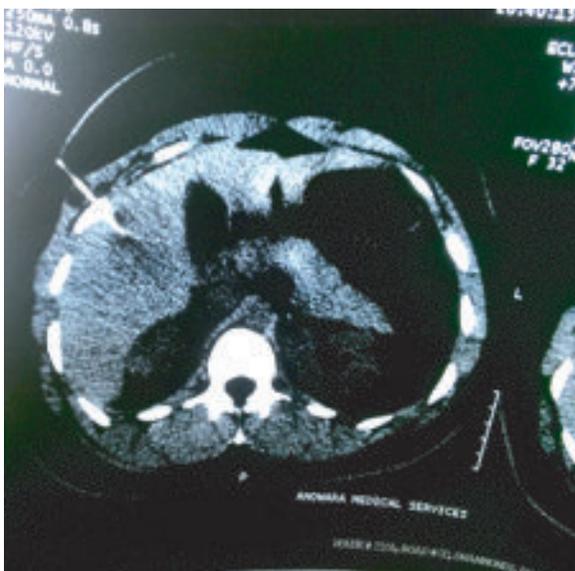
CT guided FNA from SOL of liver.
